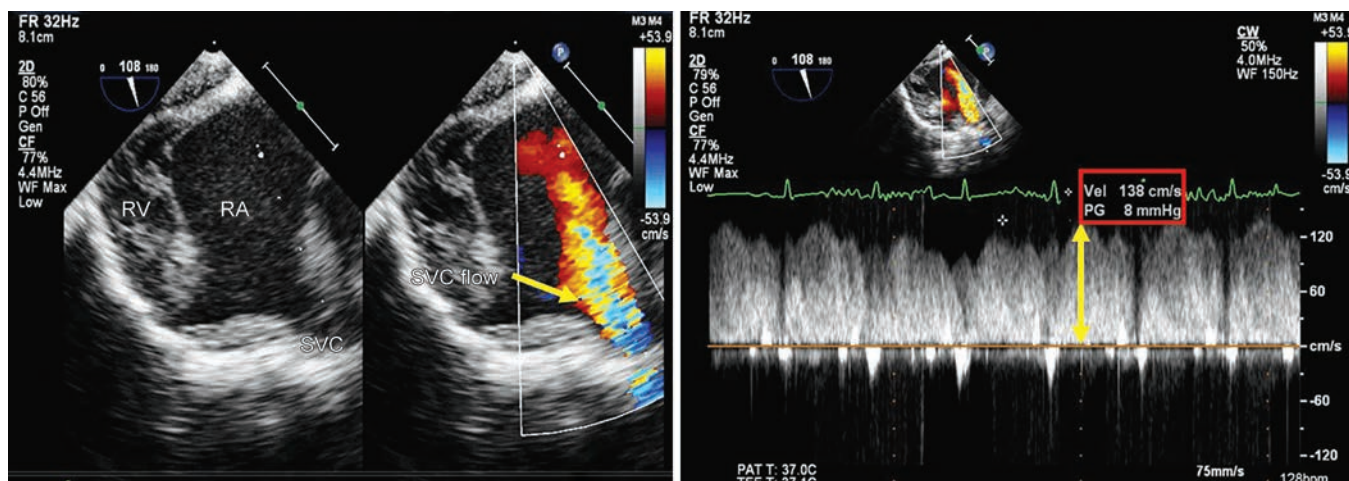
Transgastric right ventricular inflow view in post-CPB period after sinus venosus type ASD repair shows: Left panel—turbulence in SVC inflow in color Doppler; Right panel—elevated (8 mm Hg) gradient across SVC inflow, suggestive of SVC inflow obstruction. RA, Right atrium; RV, Right ventricle; SVC, Superior vena cava
